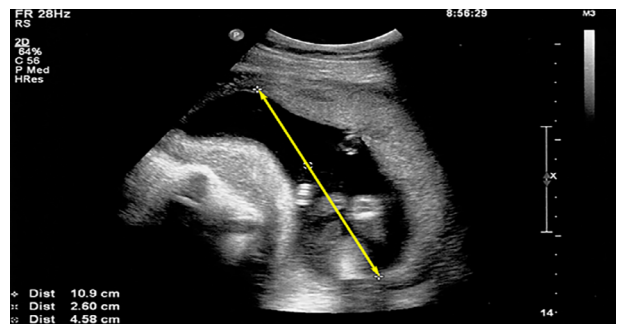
Measurement of maximal placental width (L) in crescent-shaped placenta with the ultrasound probe positioned perpendicular to the placental surface.
